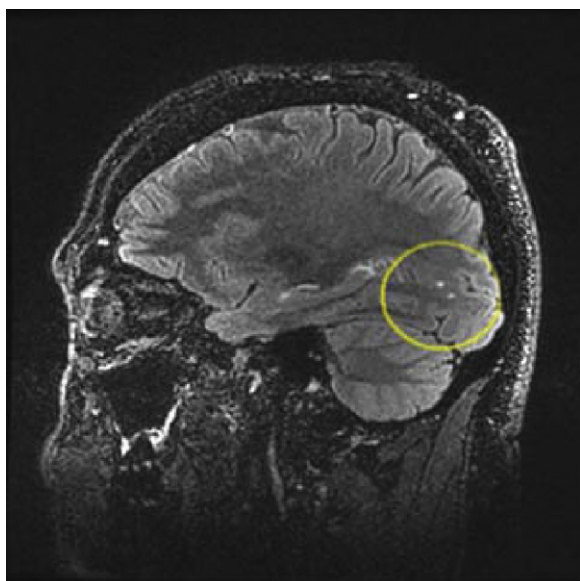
Left sagittal view of the brain MRI revealing small occipital hyperintensities.
